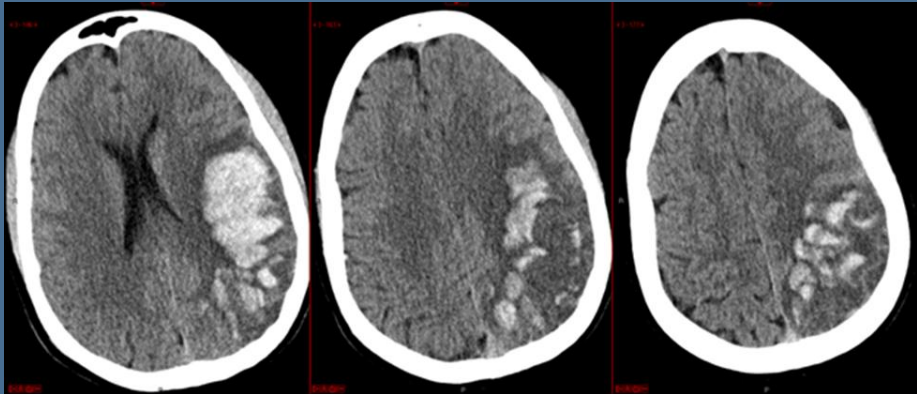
Initial CT showing massive confluent hemorrhagic infarct in left cerebral hemisphere.
